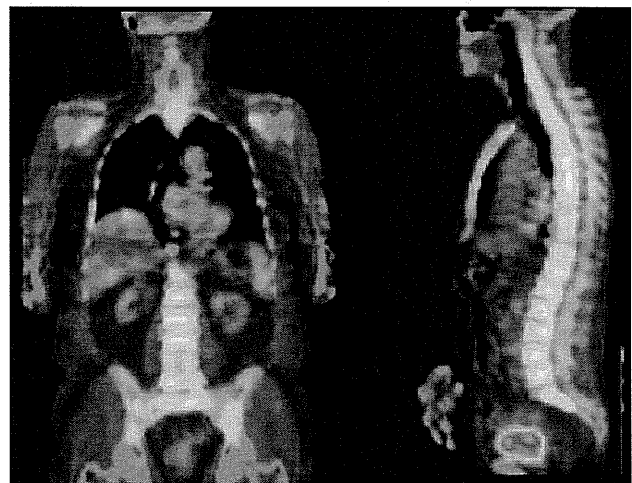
This 18 F-fluorodeoxyglucose positron emission tomography scan shows disseminated FDG uptake in the bone marrow without evidence of the involvement of other organs. Focal weak FDG uptake in the liver and the spleen was considered to be within normal range
